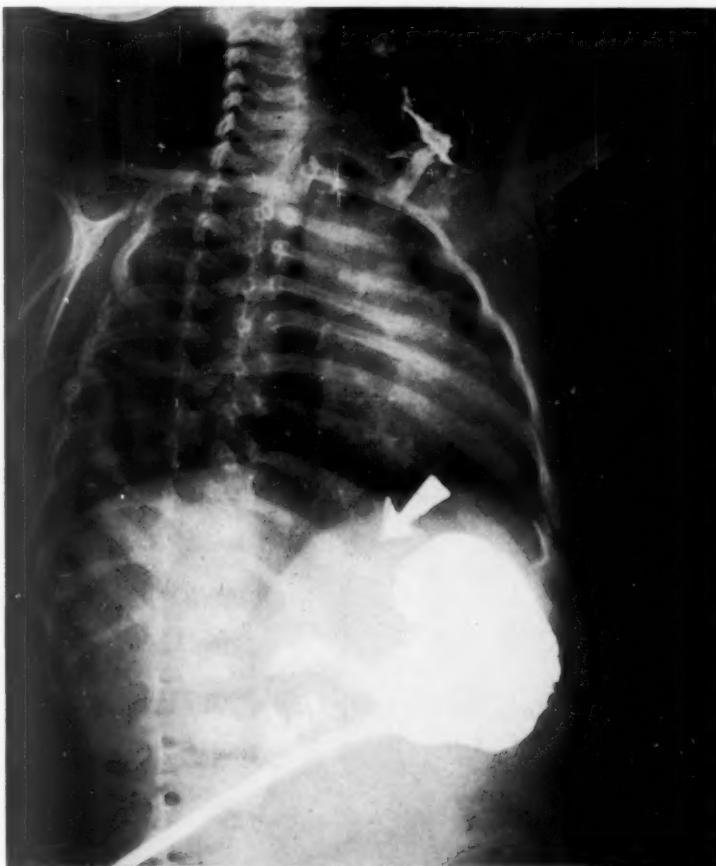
Case W. C. Pre-operative roentgenogram showing barium taken orally after spouting onto the neck through the esophageal stoma, and barium put into the stomach through the gastrostomy catheter with a faint trickle of barium extending several centimeters into the distal blind segment of the esophagus. (Arrow)
